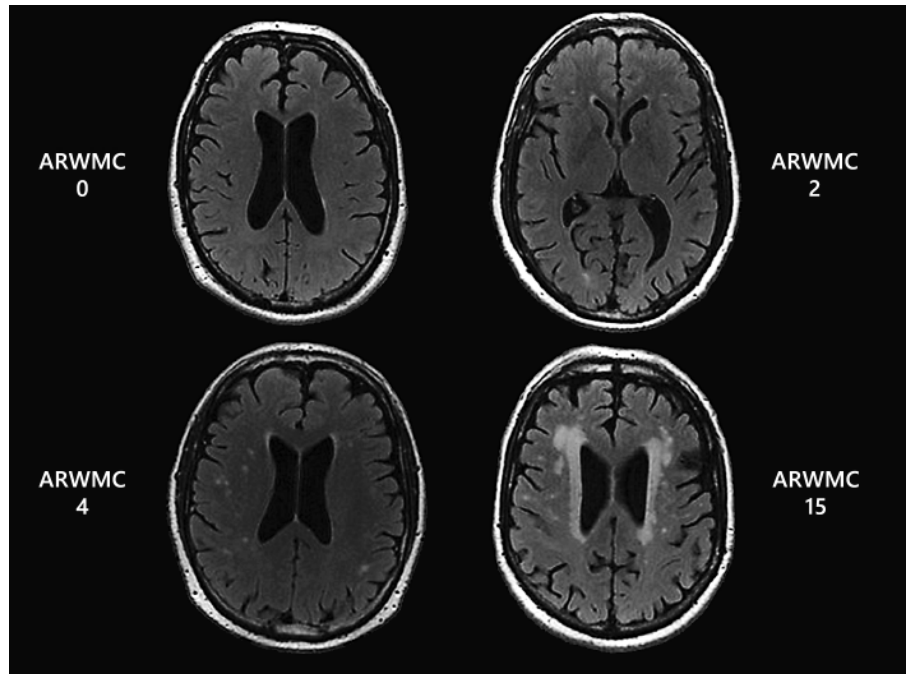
Examples of FLAIR scans of study participants with different degrees of leukoaraiosis. The ARWMC score is shown next to the images, and reflects examples for each of the quartiles used in the analysis (table 1).
